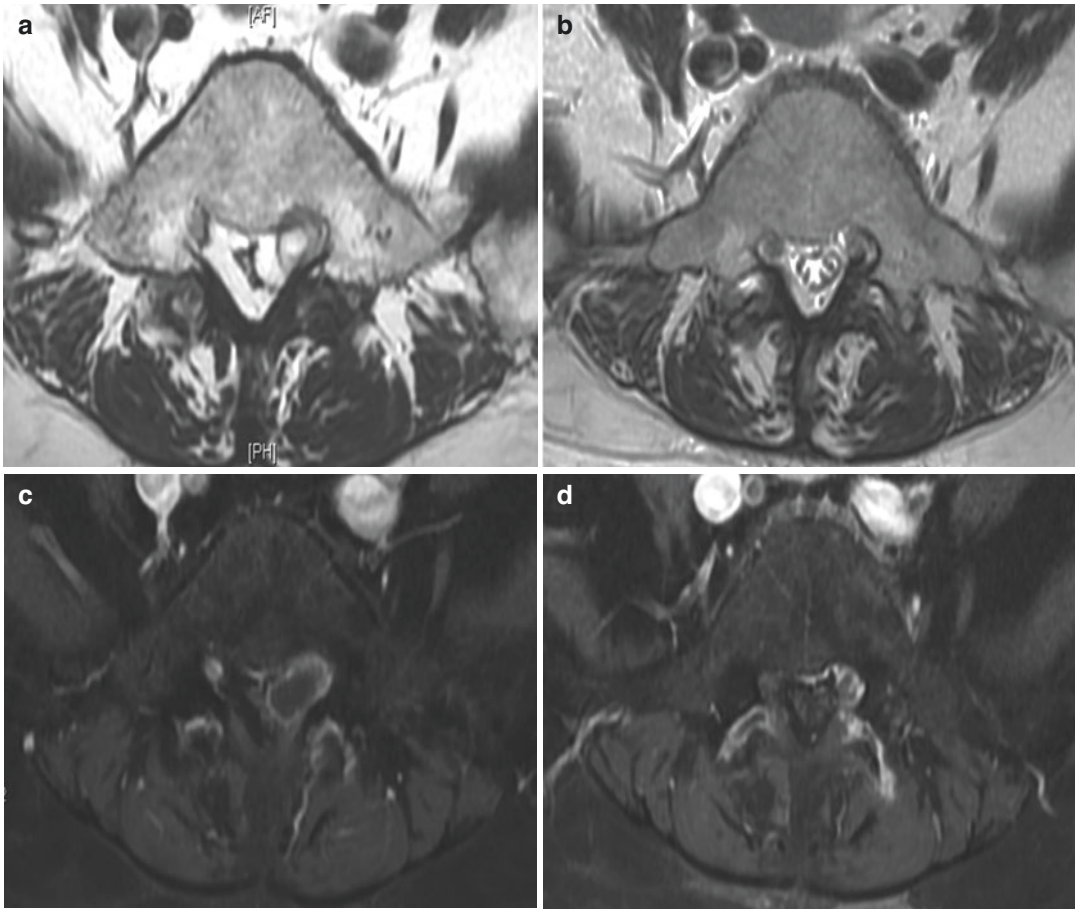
Comparison of preoperative and postoperative three months MRI findings. (a, c) Preoperative MRI T2WI images and T1WI images with contrast; (b, d) Postoperative MRI T2WI images and T1WI images with contrast
